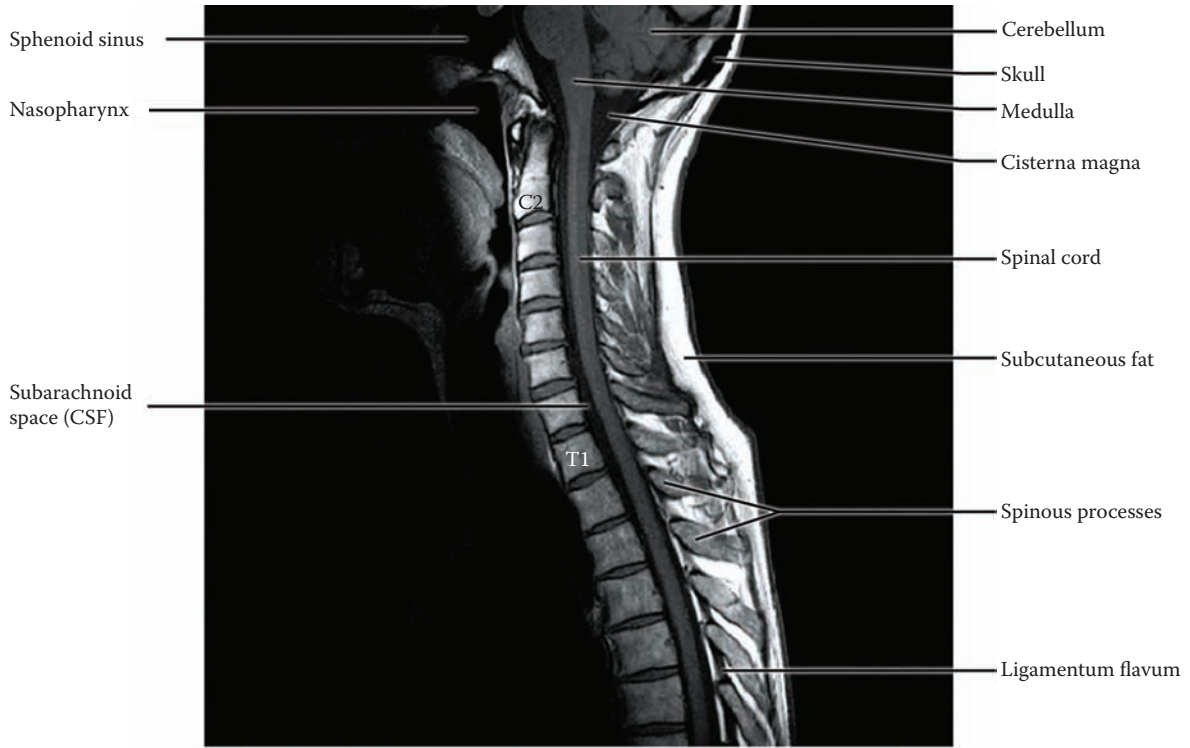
Spinal Cord 5 — MRI: Longitudinal View (radiograph)
